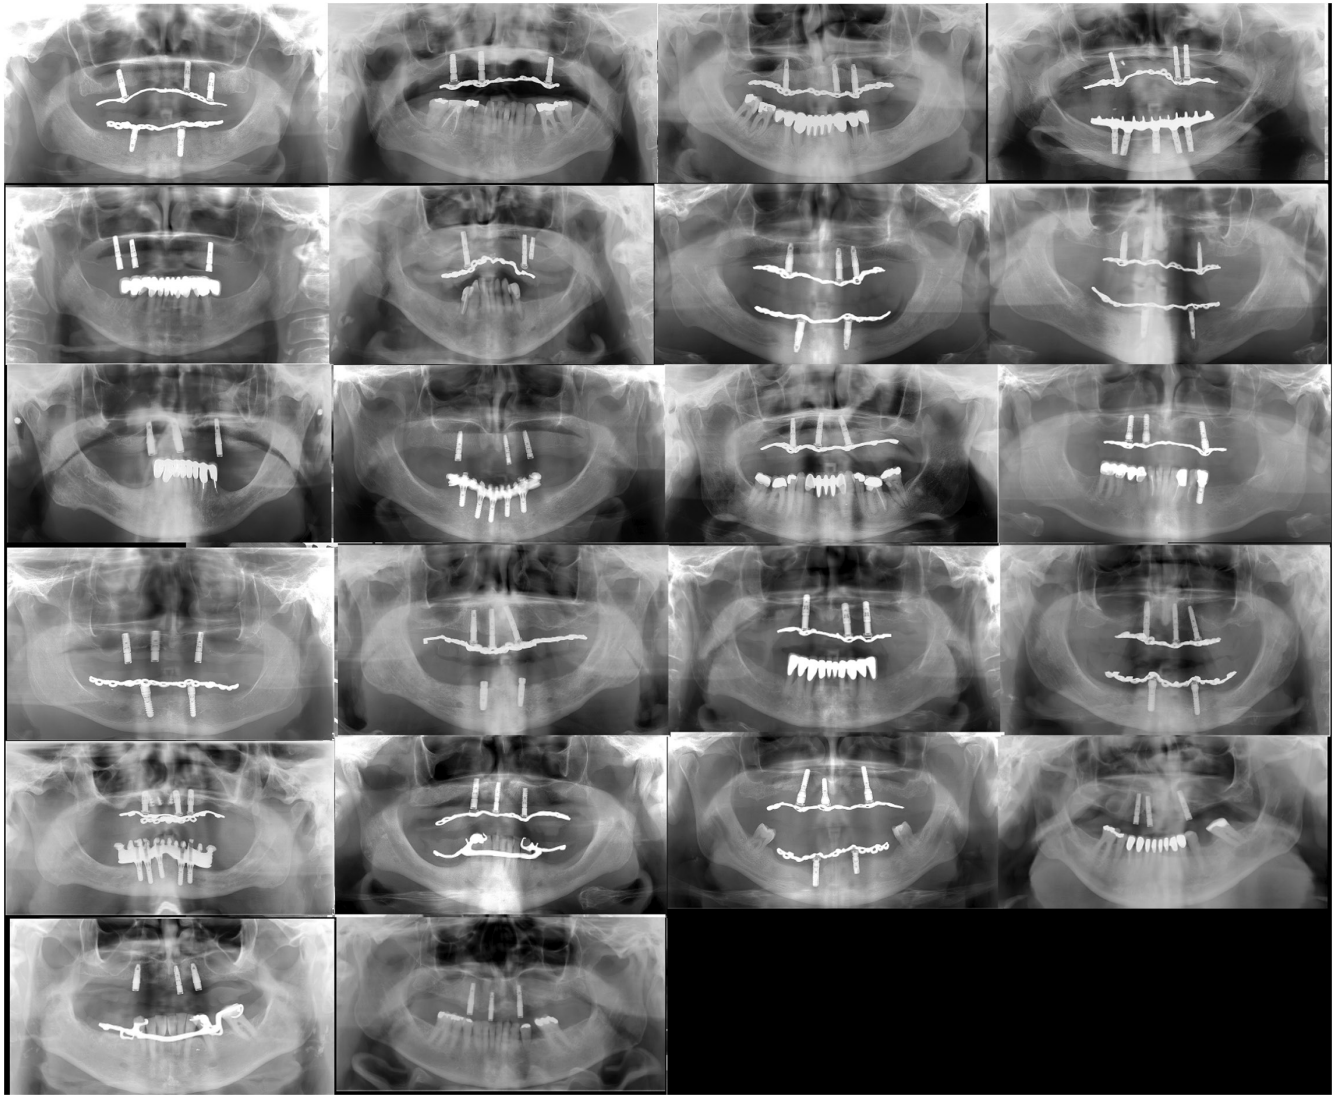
Panoramic radiographs from the latest clinical follow-up examination ($n = 23$, mean, 6.7 years (range 11–5 years)). Radiographs are sorted by the extent of the anterior–posterior spread of the three supporting implants (one flawed X-ray not shown)
